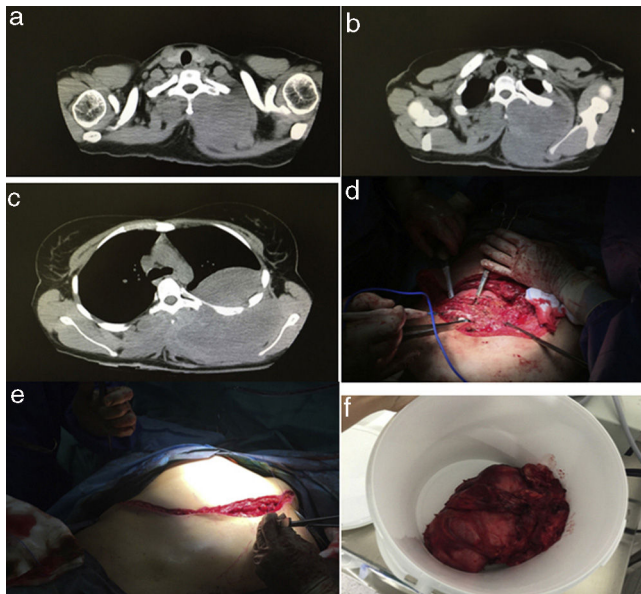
CT image of a giant desmoid tumor in the chest wall with extra- and intrathoracic growth and an image of the surgical resection.
